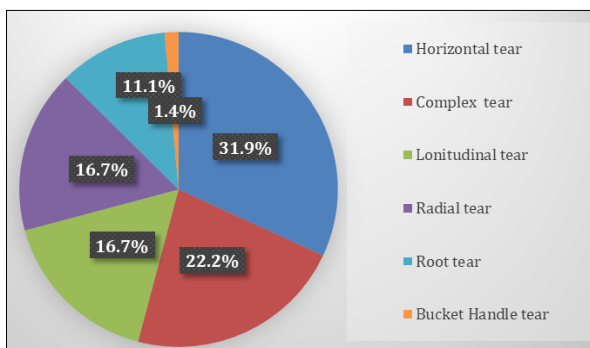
Percentage of patients with medial meniscus injury on MRI
